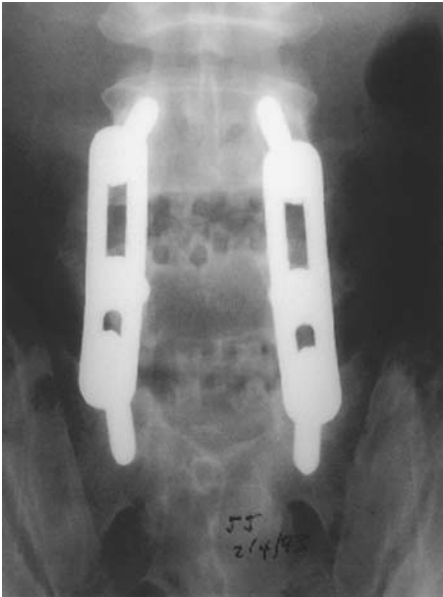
Six-month postoperative AP x-ray. The square cage struts are clearly visible, indicating that the bone density inside the cages has increased. (From Ref. 33.)
